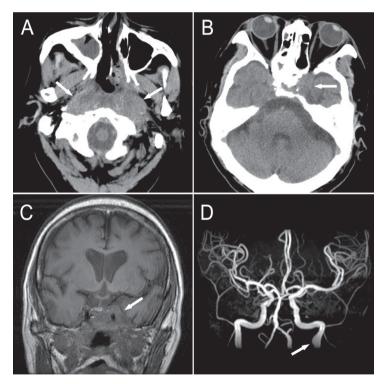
(A) Unenhanced CT images shows diffuse soft tissue thickening of nasopharynx (arrows). (B) Unenhanced CT images shows soft tissue lesion with left skull base and sphenoid bone destruction (arrow). (C) Unenhanced coronary T1-weighted brain MR image demonstrates soft tissue lesion with left skull base and sphenoid bone destruction, predominant on the left side (arrow). (D) Brain MR angiography discloses a saccular dilatation at the junction of lower part of petrous segment and distal cervical segment of the left internal carotid artery (arrow).
